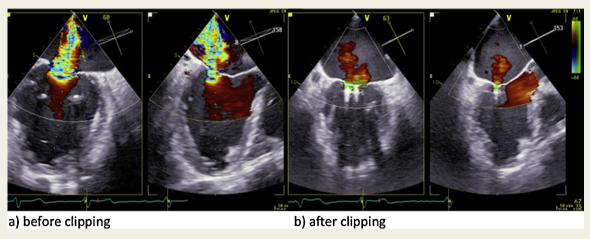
a and b) Transoesophageal echocardiography displaying significant mitral regurgitation before mitral clipping (left panel). After implantation of two MitraClips mitral regurgitation is significantly reduced (right panel).
